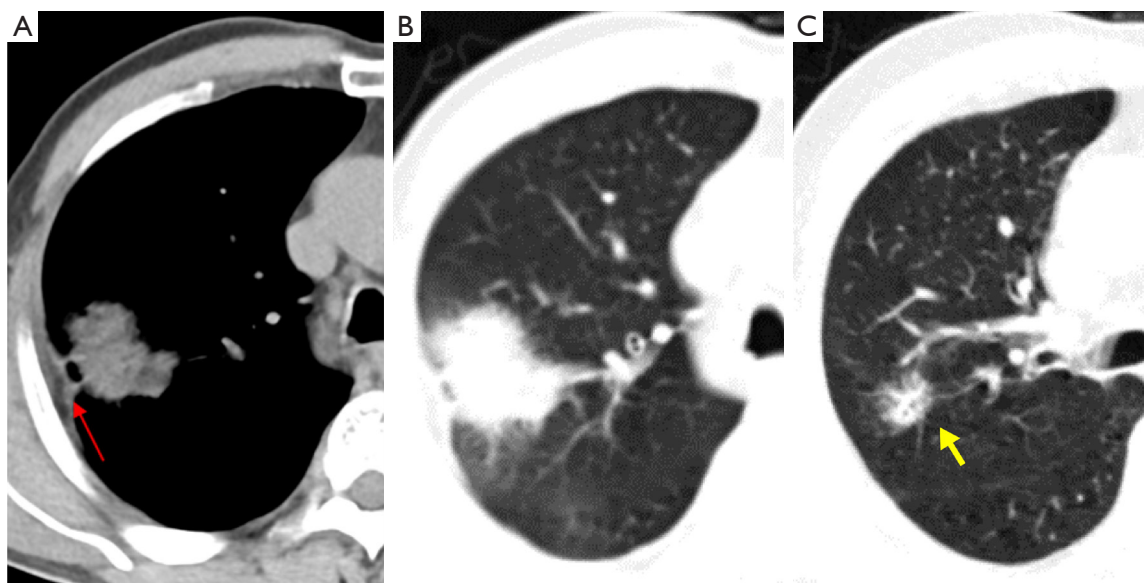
IAC. M, 71 y/o, a GGN in the superior lobe of the right lung for 3 years; mass in the posterior segment of the superior lobe of the right lung; a CT-guided percutaneous lung biopsy indicated AAH 2 years ago. (A-C) The lesion showed lobulation, the pleural indentation sign (type e, as indicated by the red arrow), and the tumor vascular sign (type IV, as indicated by the yellow arrow). The surgery was terminated 3 years ago due to pleural reactions (e.g., decreased blood pressure and arrhythmia) during the thoracoscopic surgery at another hospital. IAC, invasive adenocarcinoma; M, male; y/o, years old; GGN, ground-glass nodule; CT, computed tomography; AAH, atypical adenomatous hyperplasia.
